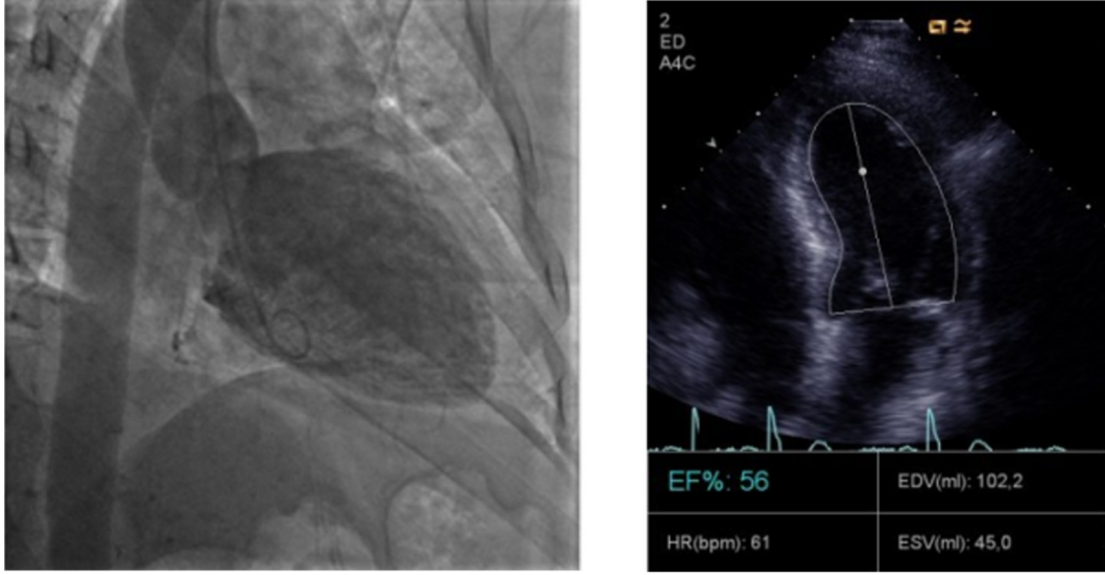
Examples of an angiographic and echocardiographic measurement of diastolic LV volume. Left: left ventriculogram during diastole taken from [16], licensed under CC BY-NC 4.0, right: echocardiogram obtained in the apical 4 chamber view during diastole taken from [62], licensed under CC BY 2.0.
